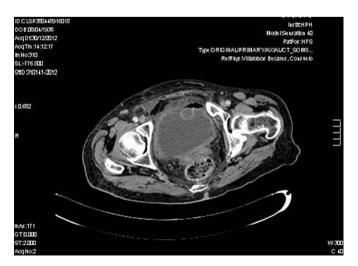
CT scan showing a large fluid collection in the pelvic cavity, suggesting lymphatic ascites.
